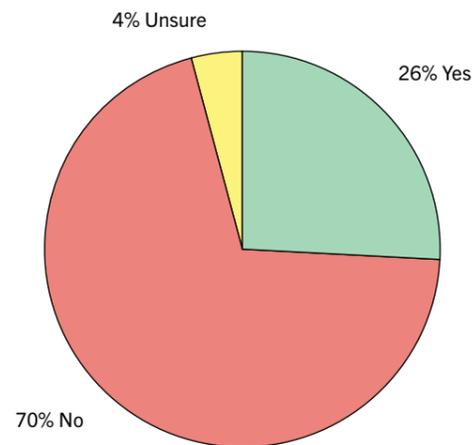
Number of radiographers who read and understood the local NHS trust policy regarding NG tube placement on CXRs
